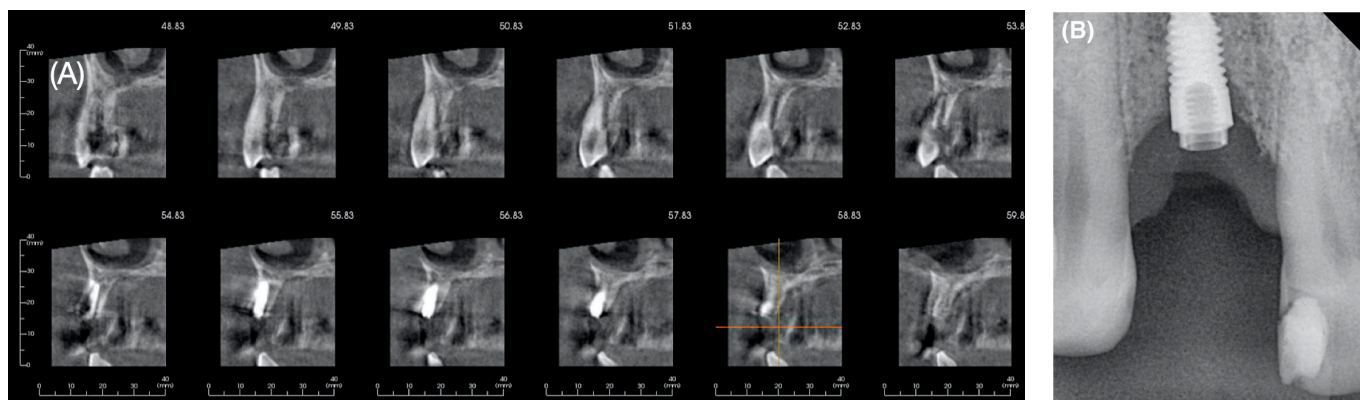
(A): Cone beam computed tomography. (B): Intraoral periapical radiograph.
